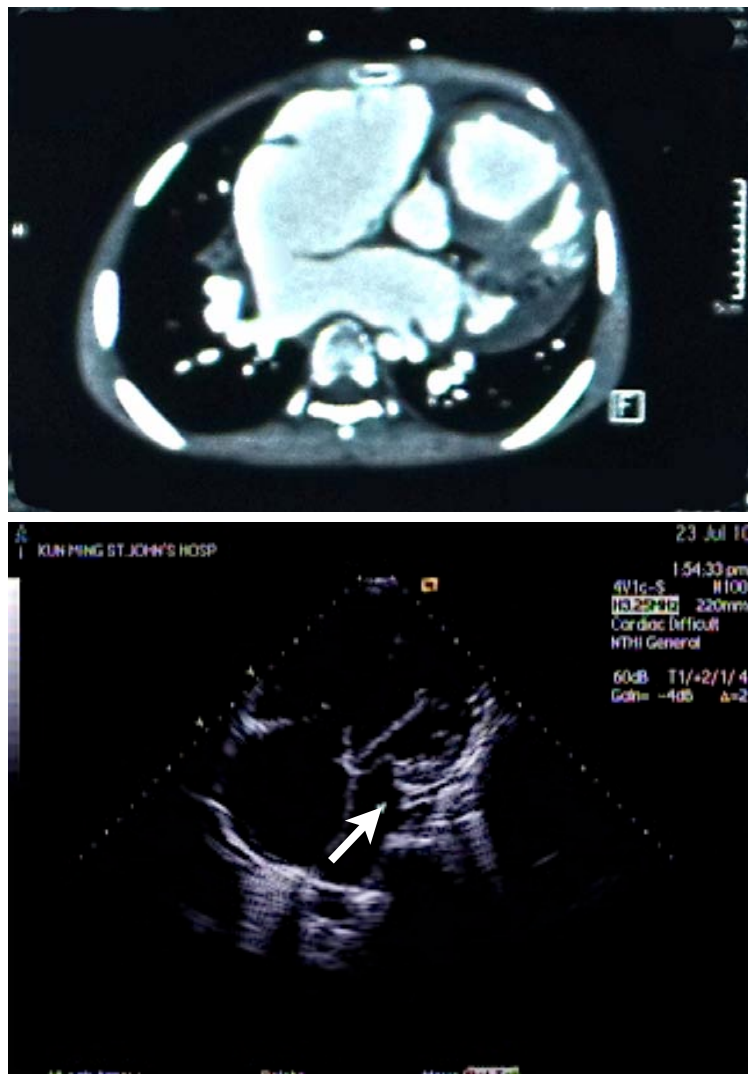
CT and echo frames of a 16 yr. old boy's heart. Arrow shows stenotic mitral valve. There is also an ASD. Right atrium and ventricle are severely dilated due to long-standing undiagnosed and untreated heart disease.
